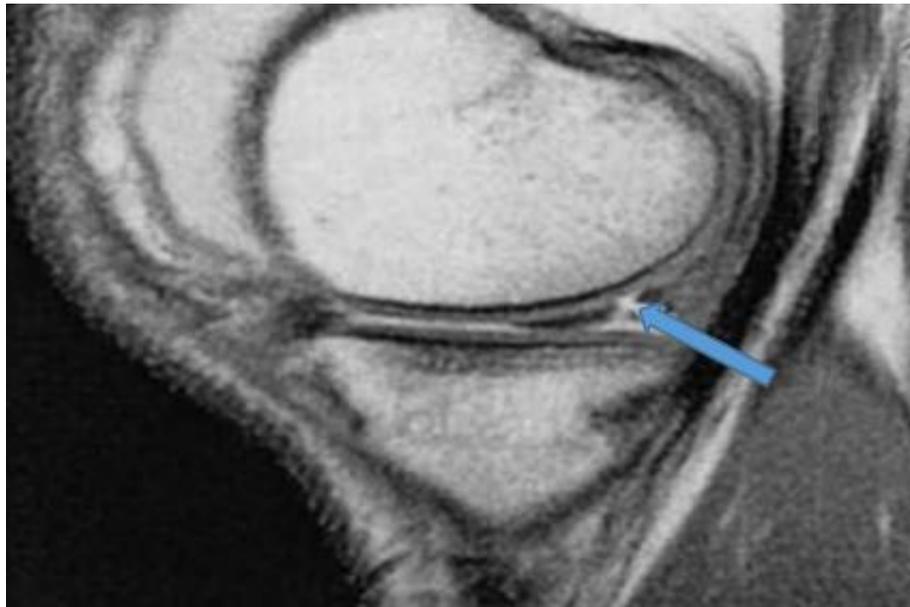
MR image of the knee joint of patient Sh., 46 years old. Sagittal projection. Vertical tear of the posterior medial horn of the meniscus. The medial meniscus is normal in shape, a vertical hyperintense line is detected in its structure
